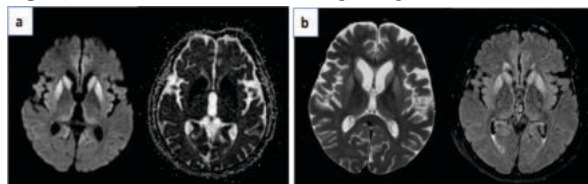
a) and b) Symmetric diffusion restriction and T2/FLAIR hyper
